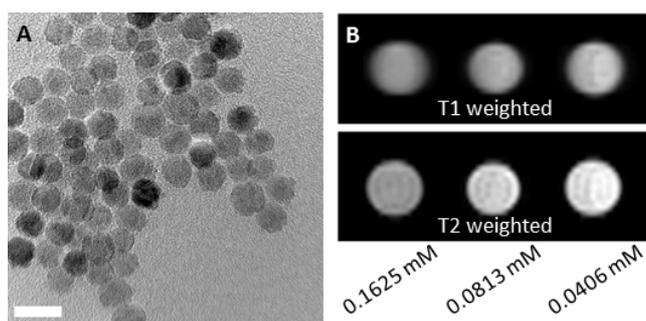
TEM (A; scale bar = 20 nm) and MRI (B) T₁ and T₂ weighted images of P1b* modified IONPs at different concentrations.
